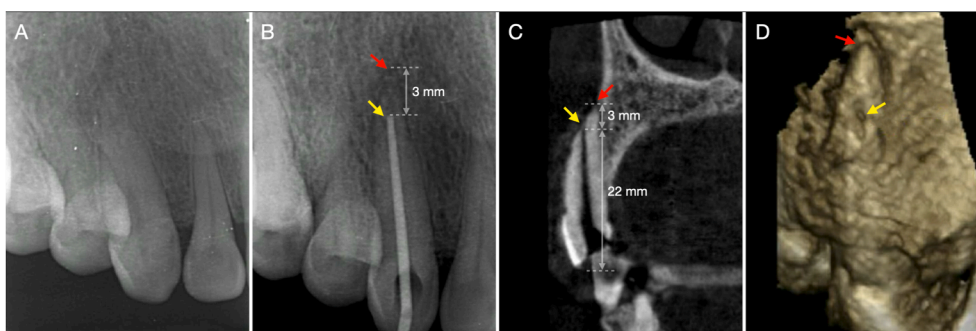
(A) Pre-operative periapical radiograph. (B) Working length confirmation radiograph showing the gutta-percha cone (Yellow arrow: apical foramen by the apex locator) approximately 3 mm short of the apex (red arrow: radiographic apex). (C) Sagittal section of a cone-beam computed tomography (CBCT) image showing the apical foramen (yellow arrow) located approximately 3 mm short of the radiographic apex (red arrow). The distance from the cusp (reference point) to the apical foramen is approximately 22 mm. (D) Three-dimensional reconstruction of the CBCT image showing the relative position of the apical foramen (yellow arrow) and the radiographic apex (red arrow).
